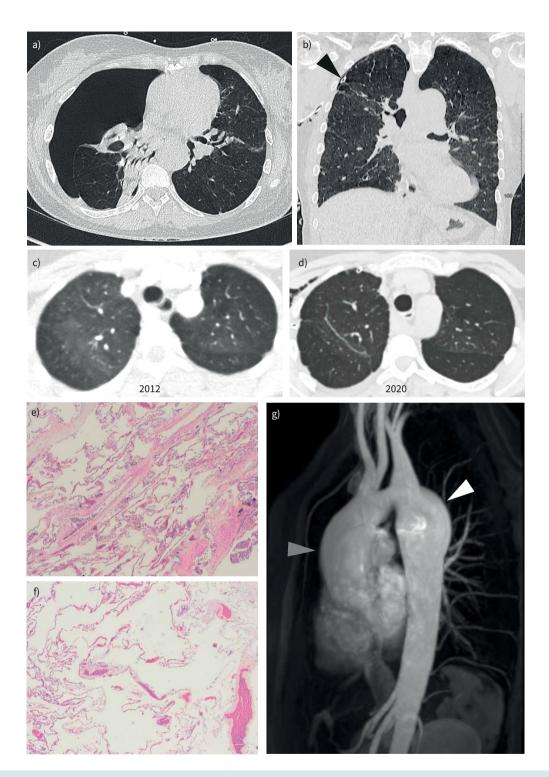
Filamin A (*FLNA*) loss-of-function. a) Single axial computed tomography (CT) slice of the lower chest shows large right pneumothorax with shift of the mediastinal structures to the left and collapse of the right lower lobe. b) Coronal reformat of unenhanced CT chest after drain insertion (arrowhead) with near complete reinflation of the right lung. CT shows bilateral apical predominant emphysema and lobular areas of reduced attenuation and hypovascularity, with overinflation of secondary pulmonary lobules most in keeping with small airways obstruction. c) CT from 2012 performed for assessment of the aorta and d) 2020 showing a reduction in density of the lung parenchyma with progressive overinflation: 100×. f) Congested vessels. Magnification: 100×. g) Maximum intensity project magnetic resonance image of the thoracic aorta demonstrates mild dilatation of the ascending aorta up to 36 mm diameter (grey arrowhead) and of the distal arch/proximal descending thoracic aorta up to 42 mm diameter (white arrowhead). Normal aortic diameter would be 20–30 mm. Incidental anomalous retro-oesophageal course of the right subclavian and common origin of the brachiocephalic artery and left common carotid arteries.
